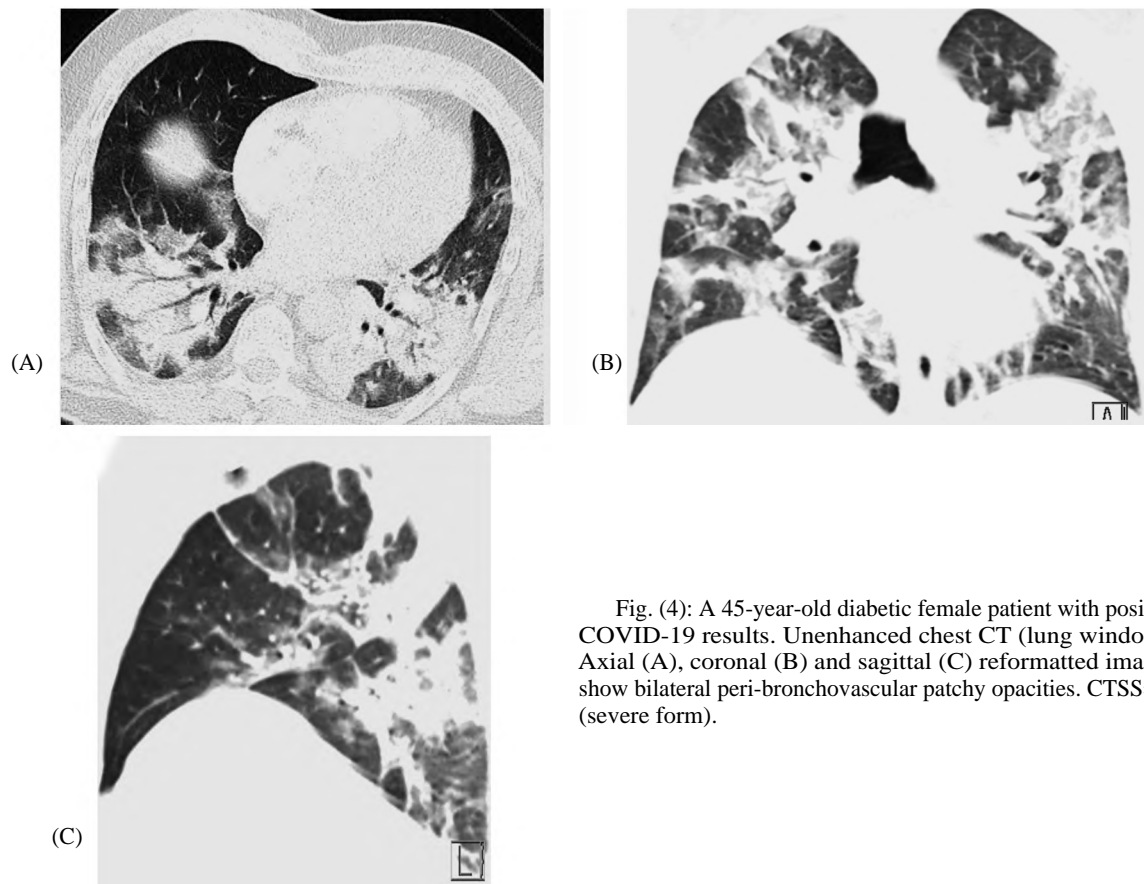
A 45-year-old diabetic female patient with positive COVID-19 results. Unenhanced chest CT (lung window), Axial (A), coronal (B) and sagittal (C) reformatted images show bilateral peri-bronchovascular patchy opacities. CTSS=22 (severe form).
